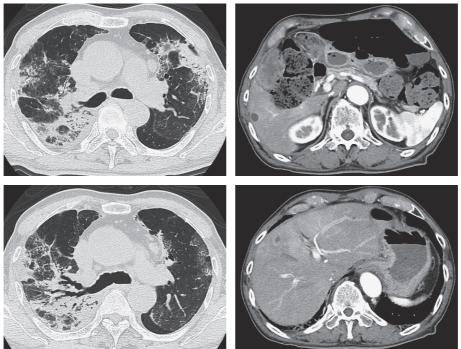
Chest and abdominal CT images: Bilateral, upper lobe-predominant, and peripheral consolidative and ground-glass opacities were shown by chest high-resolution CT (A). Abdominal contrast-enhanced CT also revealed border irregularity and wall thickening of the gallbladder and ringed enhancement of LDAs in the liver (B).
